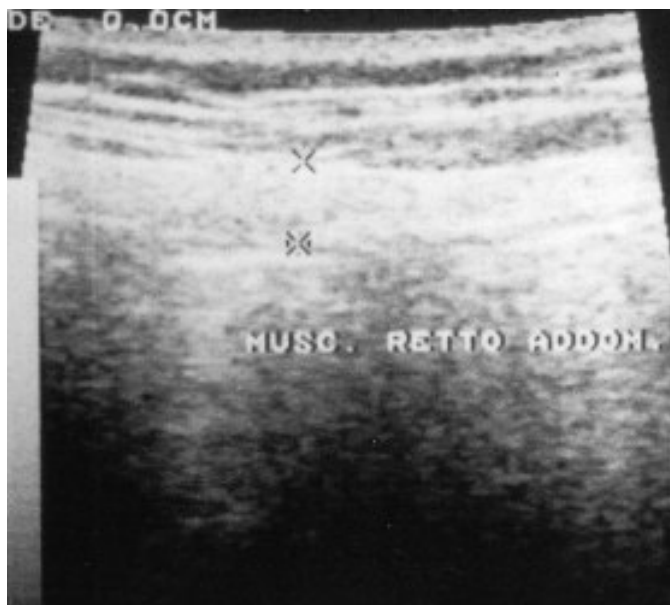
Ultrasound image of the abdominal wall, from the patient in supine position (parasagittal section): right rectus abdominis muscle shows no pathological elements.
